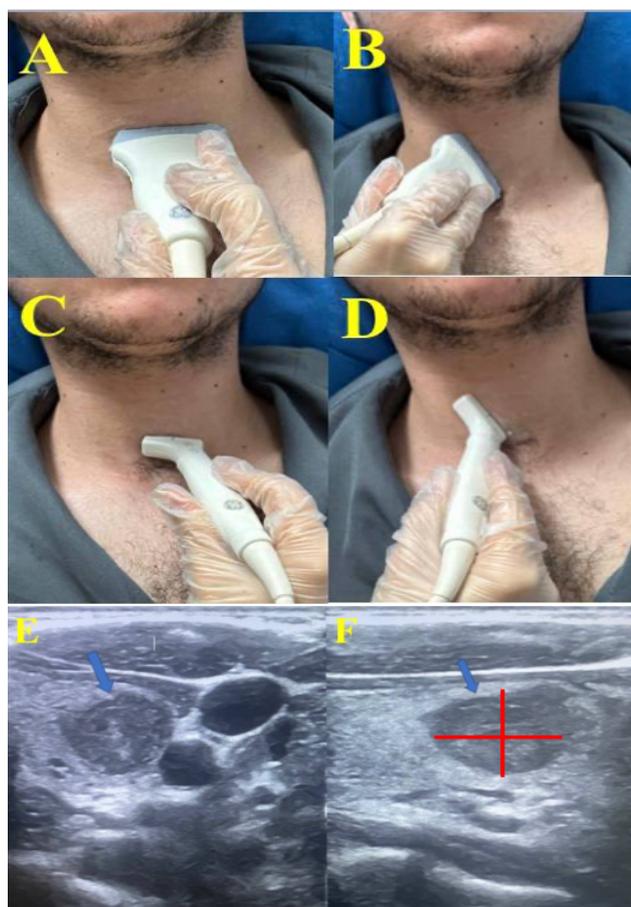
The examination protocol of the thyroid gland (A) and (B) axial and longitudinal planes using a linear probe. (C) and (D) axial and longitudinal planes using a hockey stick transducer. (E) and (F) ultrasonic photos of the Left thyroid lobes show how the nodule (blue arrows) appears in the (E) axial plane and (F) longitudinal plane. The measurement of the nodule area is obtained by estimating two measurements which are the length and the width (red arrows).
